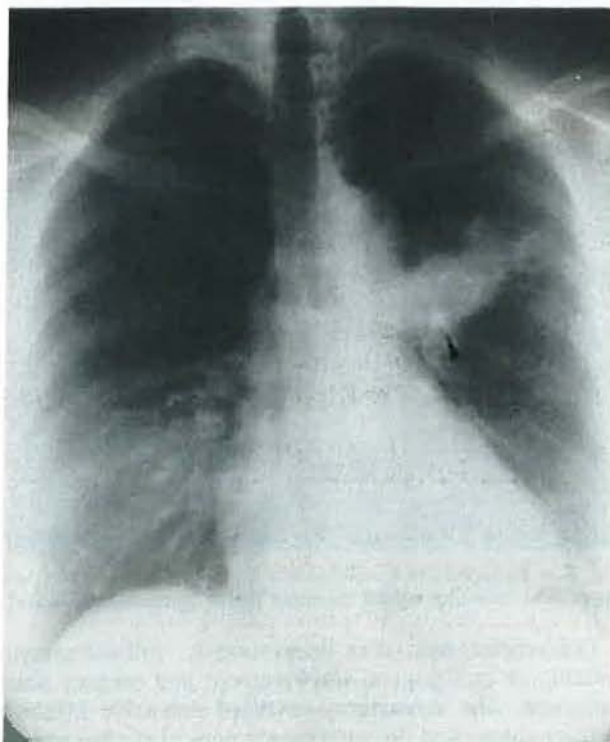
Chest X-ray shows an infiltrate in the anterior segment of the left upper lobe with possible calcification (arrow) at its origin.
